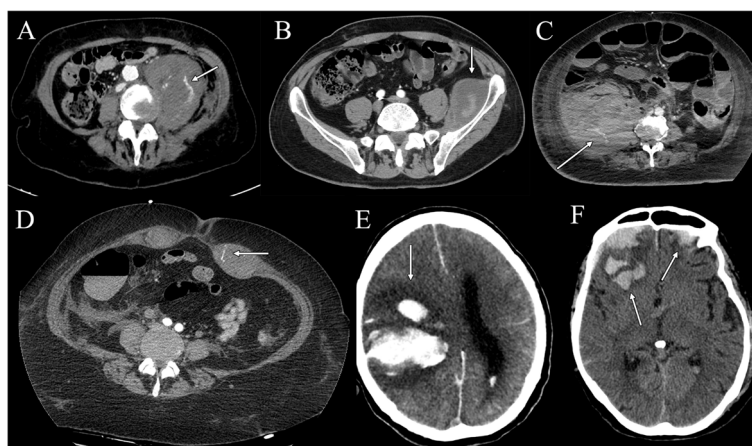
Axial contrast-enhanced CT images of different patients with COVID-19 admitted to ICU with extensive bleeding in the ilio-psoas muscle (arrows in A, B and C); note the presence of arterial blush referable to active bleeding in A and C. Axial contrast-enhanced CT image of another COVID-19 patient with active bleeding of the left rectus abdominis muscle (arrow in D). Axial contrast-enhanced CT showing a spontaneous massive intracerebral hemorrhage with surrounding edema and significant midline shift (arrow in E). Axial contrast-enhanced CT of another COVID-19 patients admitted to ICU demonstrating an intracerebral hemorrhage located in both frontal lobes (arrows in F)
